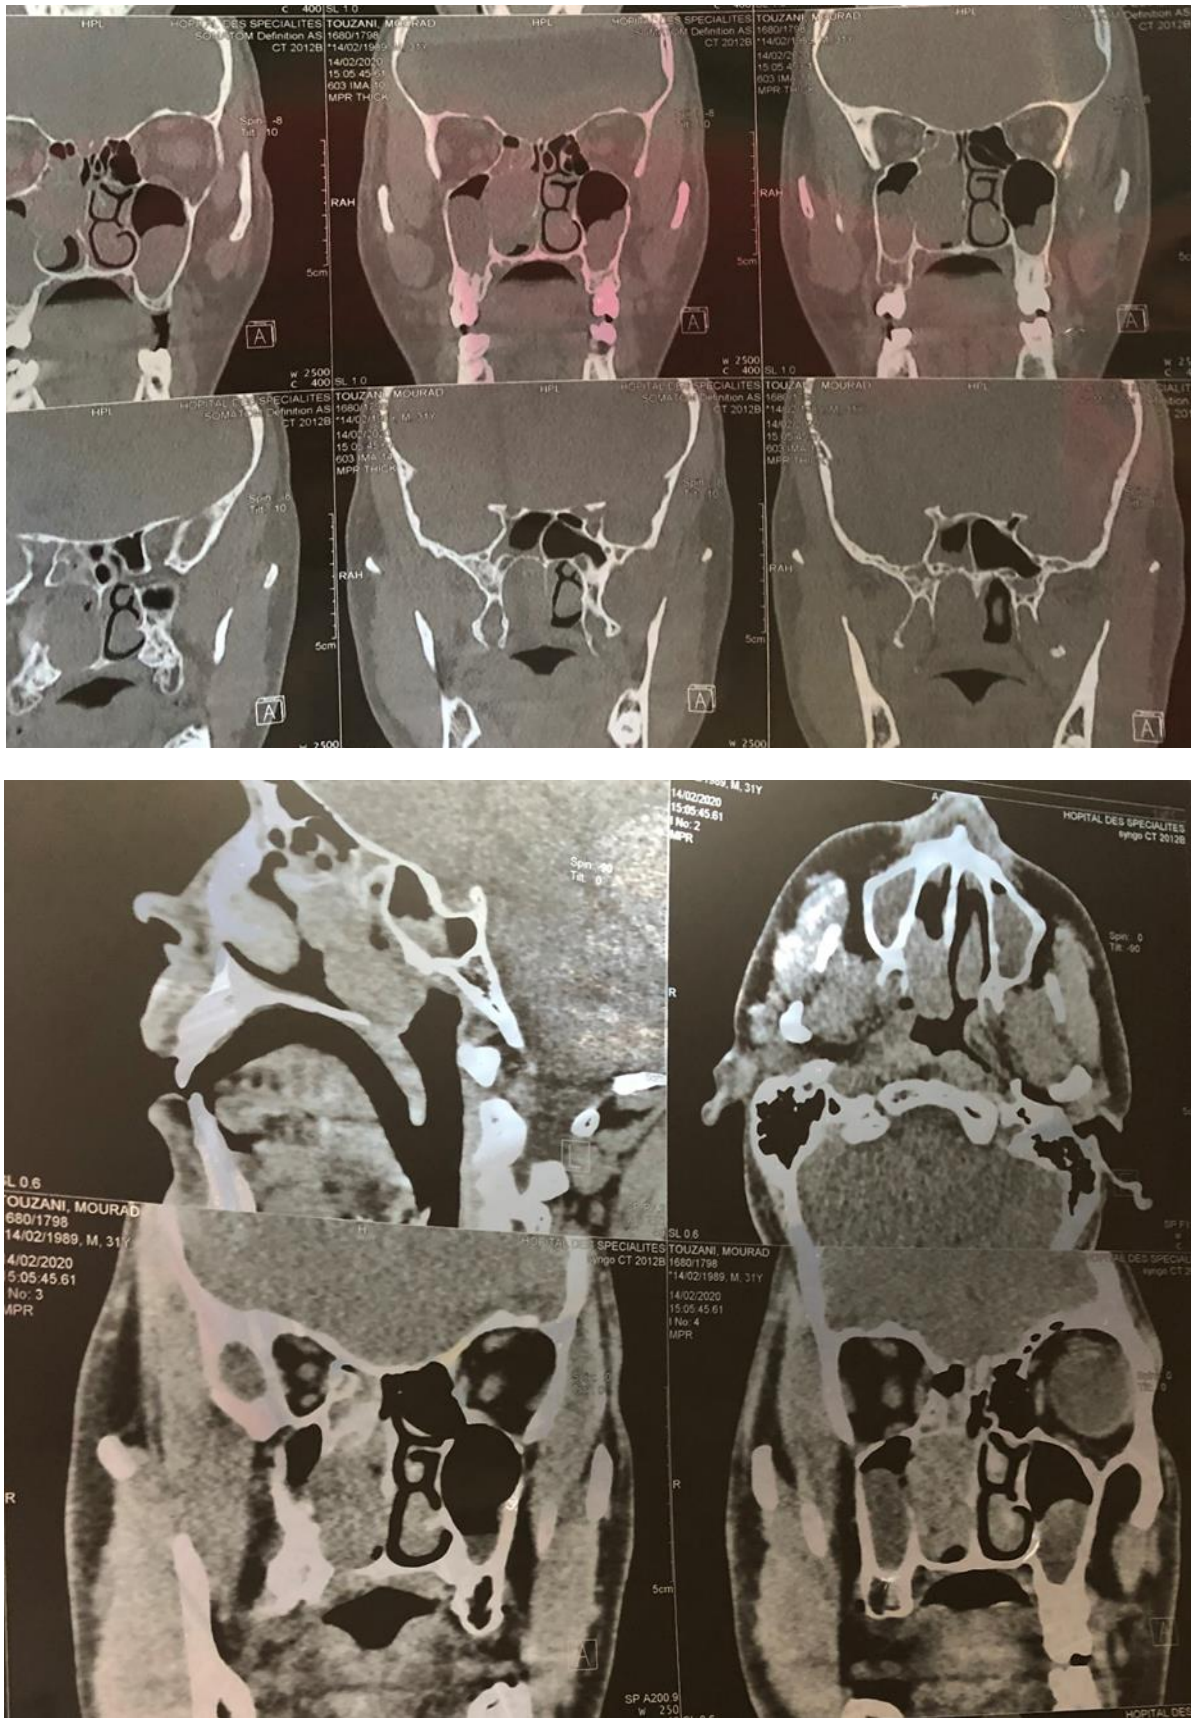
coronal and axial cuts of the patient's nasosinusian CT disease showing tissue density mass at the right nasal cavity.
